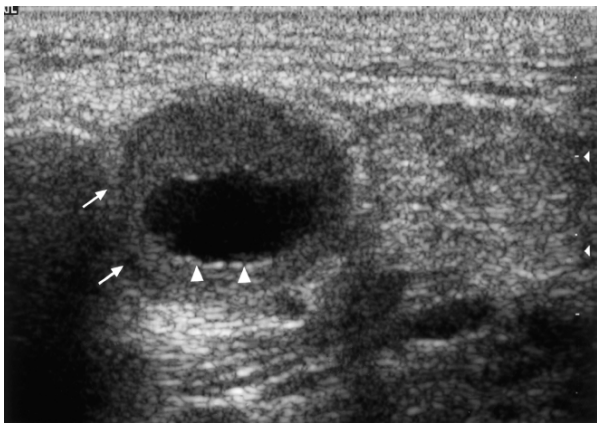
Sonogram of a metastatic node (arrows) with intranodal cystic necrosis (arrowheads).
